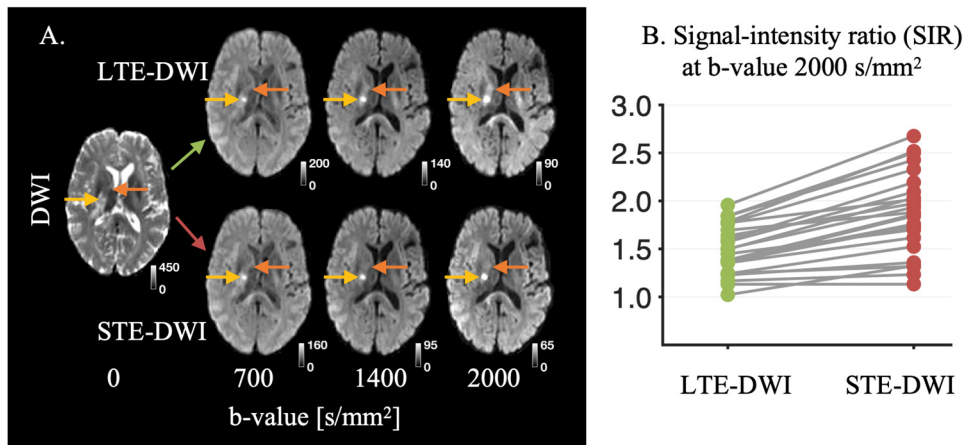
Contrast mechanism of STE and increased conspicuity in gliomas. Panel A shows that at higher b -values STE attenuates white matter more than LTE compared. Orange arrows: corticospinal tract, yellow arrows: glioma tumor-related hyperintensity. Panel B shows that the signal-intensity-ratios (SIR) obtained by conventional encoding (LTE-DWI) and spherical tensor encoding (STE-DWI) at a b -value of 2000 s/mm². In all (100 %) cases, the SIRs from STE-DWI were higher than those obtained by LTE-DWI (median \pm standard deviation; SIR 1.46 \pm 0.24 vs 1.91 \pm 0.40; paired Wilcoxon signed-rank test, $p < 10^{-4}$). Figure adapted from Paper III, published by Frontiers Media licensed under CC BY 4.0.
